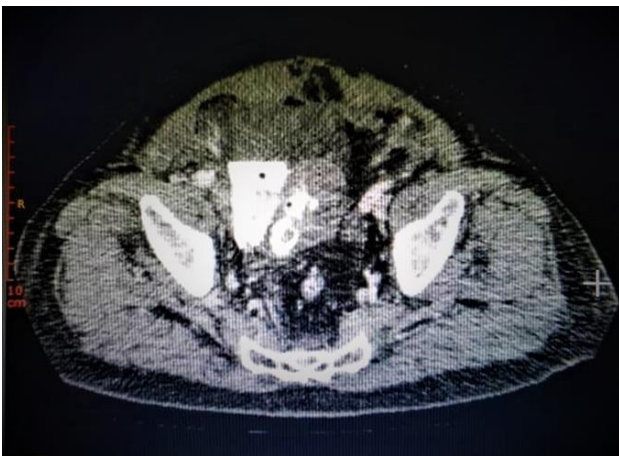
(Pre-operation CT imaging) contrast was pooled in the right hemipelvis; bladder wall defect noted measured 1.2 cm; hyperdensity within urinary bladder suggestive of hematoma.; multiloculated fluid collection with extensive air locules at suprapubic and lower abdomen (mainly at the extraperitoneal space).
